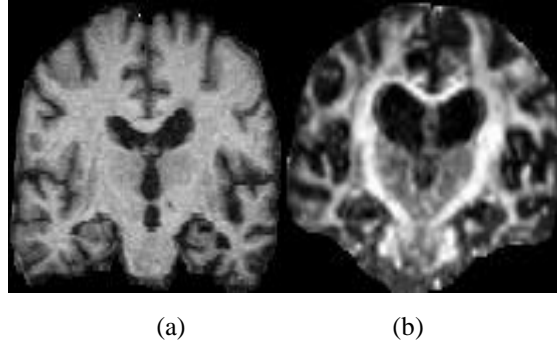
(a) Segmented brain from MRI slice (b) Segmented brain from DTI slice.
